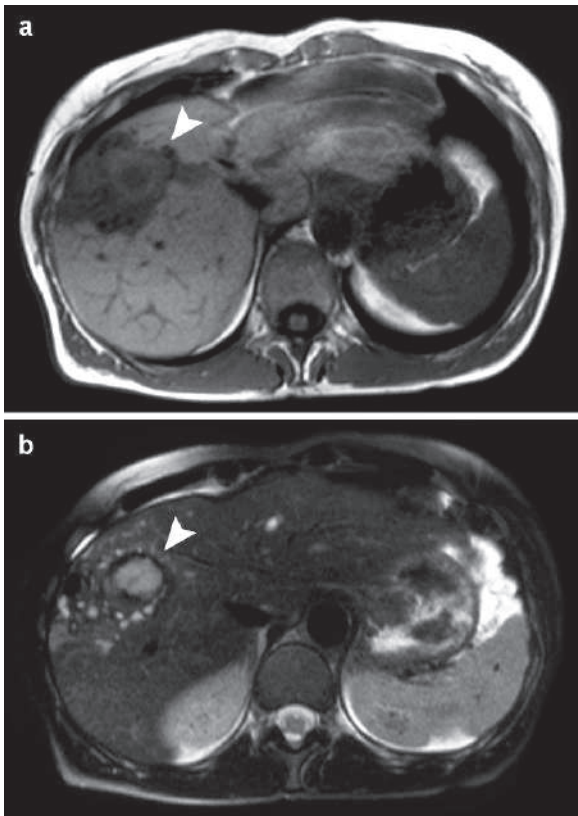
Axial T1W (a) and T2W (b) nonenhanced MR images in a patient with *Echinococcus alveolaris* disease show a mass that resembles HCC (arrowheads), with multiple cystic lesions within the mass. Notice that the mass bulk is hypointense on T2W image (b) due to the fibrous (keloid) nature of the lesion
